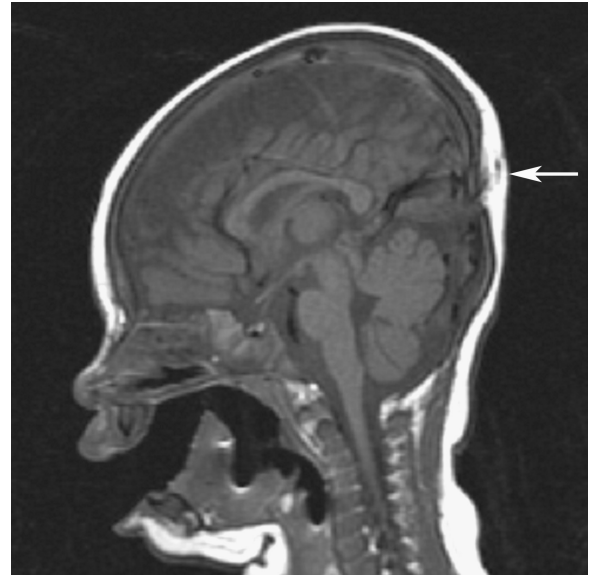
T1-weighted brain MRI of the patient at age 6 months. The arrow indicates the location of the atretic parietal meningocele overlying a persistent falcine sinus. There were no other structural abnormalities of brain.
